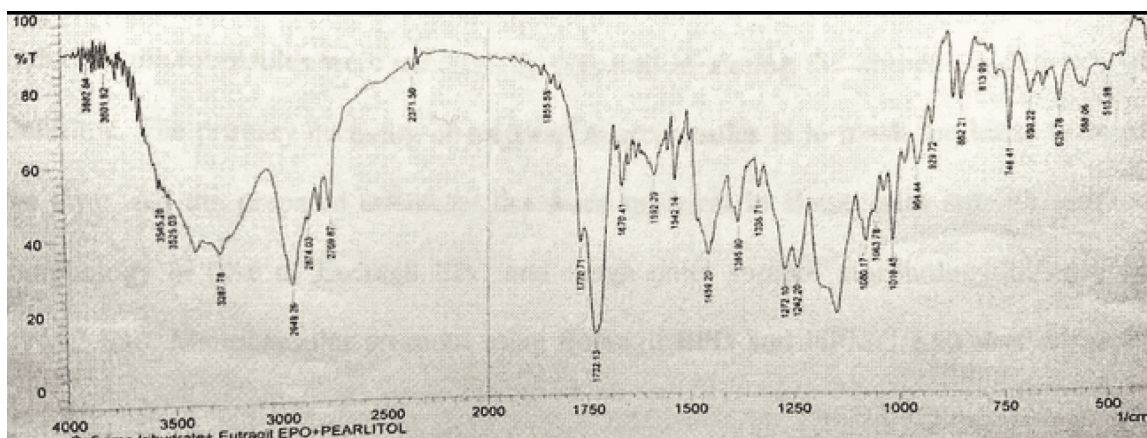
FTIR of FF6 ODMTs (CT + optimised EPO microcapsules + pearlitol)
